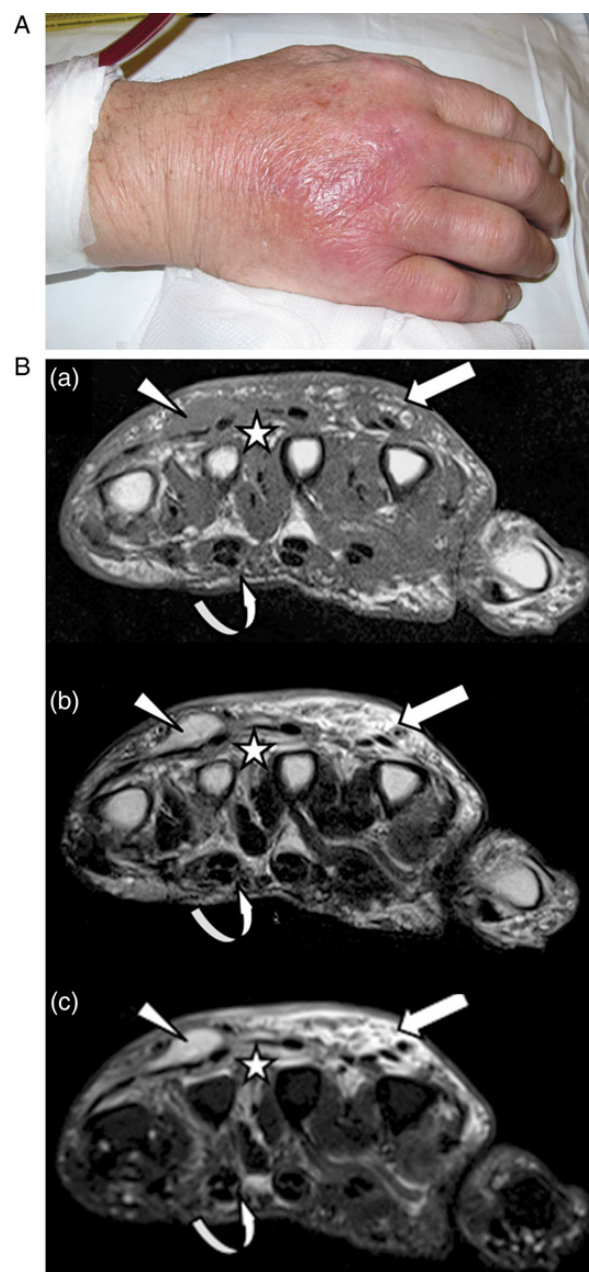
(A) Erythematous, nodular lesion on the back of the right hand, distal to the AVF. (B) Transverse (a) T1-, (b) T2- and (c) short tau inversion recovery (STIR)-weighted magnetic resonance imaging. Images at the level of metacarpal bones show severe infiltration of the dorsal soft tissues and extensor tendon sheaths (arrows), with areas of confluence corresponding to abscesses (arrowheads) and extension within the interosseous spaces (star) and volar tendon sheaths (curved arrows).
